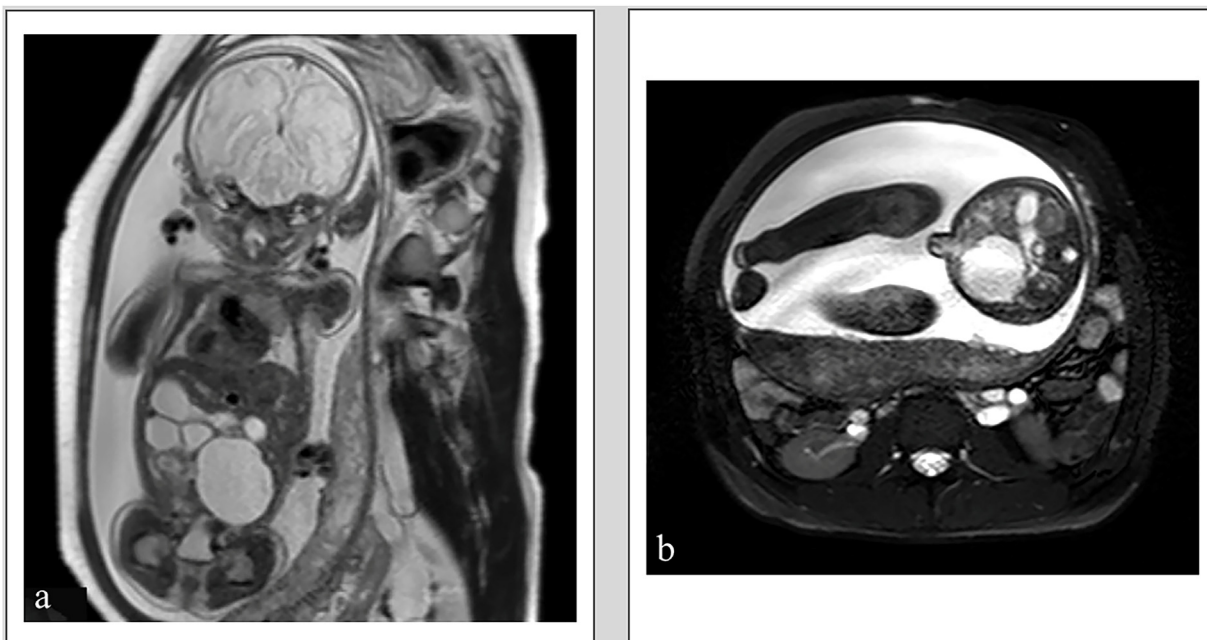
Magnetic resonance imaging shows the dilated small intestine (a) and the cystic lesion (b).
